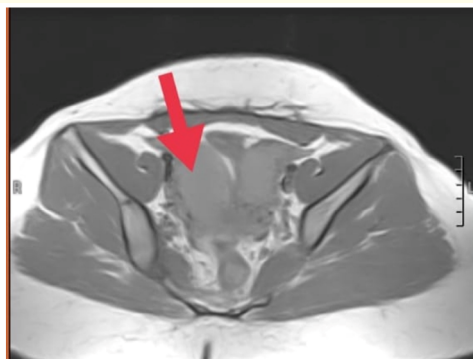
MRI axial section of the pelvis showing the right uterine horn (red arrow) and separating triangular shaped soft tissue (blue arrow).
